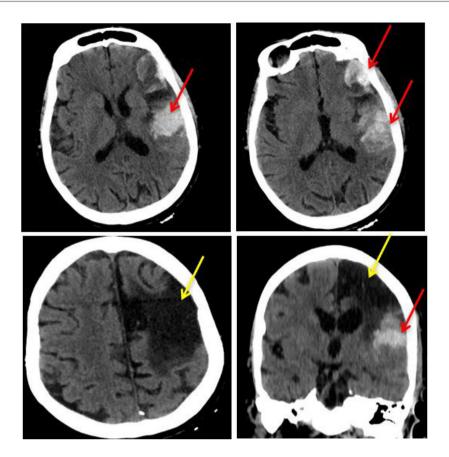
Computed tomography of the brain with the underlying progression of neurological symptoms: hemorrhage into the area of ischemic alterations after past acute cerebrovascular event in 2005.
